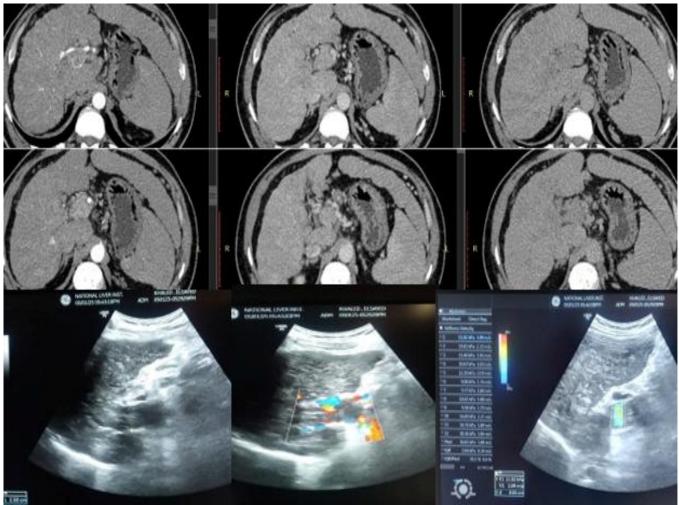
Malignant PVT by CT and US-SWE
